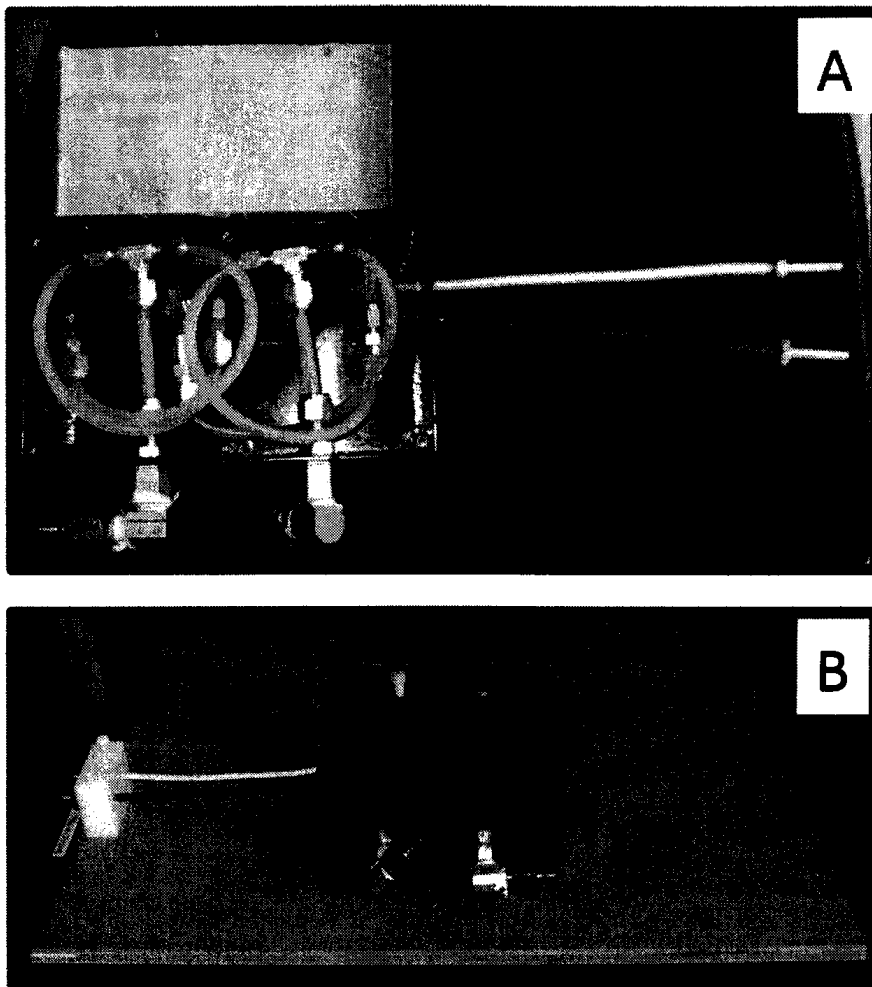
(A) Cooling and electrical system for potted coil. (B) Press board insert and terminal block designed to fit on the patient bed of the 1.5 T MRI system.
